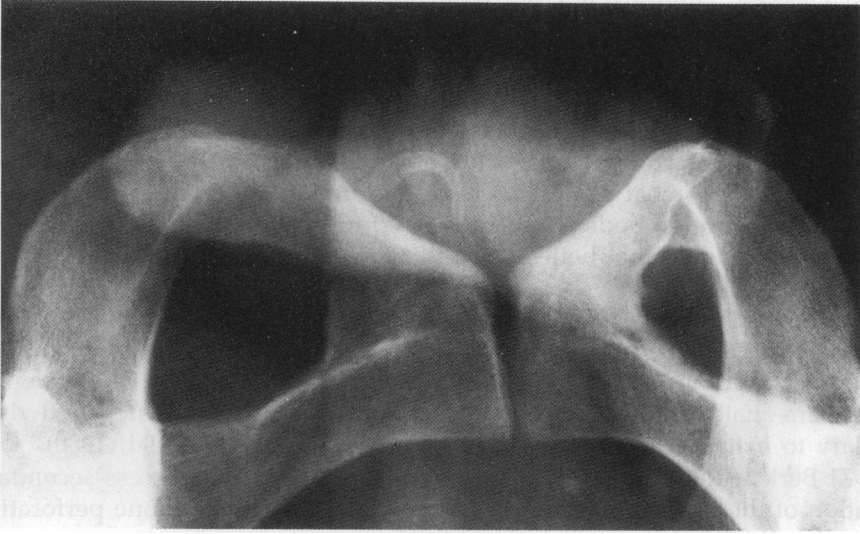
Plain abdominal radiograph of patient.
